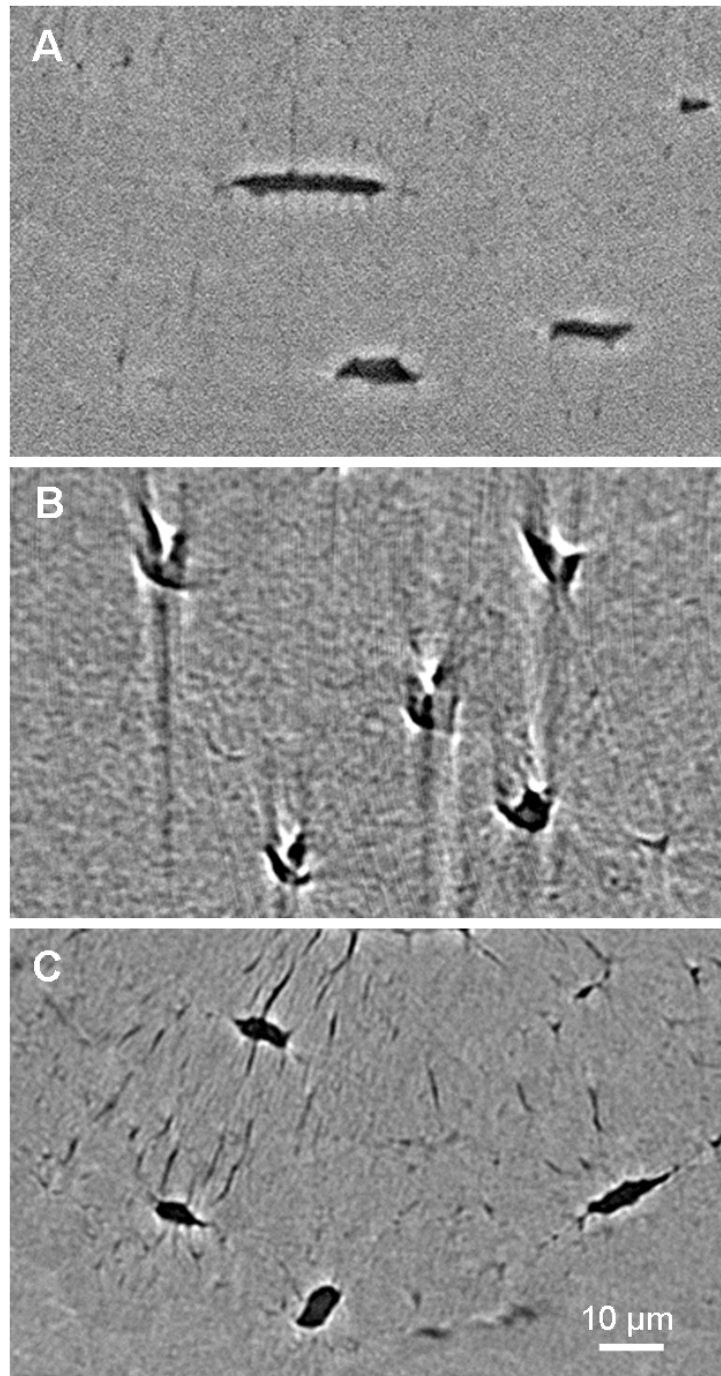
Regions in slices extracted from the 3D images acquired with different imaging configurations, showing the impact of the imaging set-up and of the acquisition conditions on the visibility of canaliculi. A: If the detector efficiency and its point spread function are not optimal, the reconstructed images are corrupted by noise, low contrast and partial volume effects. B: If the X-ray flux is increased in order to compensate for the low efficiency of the detector, the augmented level of the radiation dose causes sample shrinkage and micro-crack propagation, resulting in motion artifacts. C: The optimization of the detector and of the acquisition parameters enables imaging of the lacuno-canalicular network.
